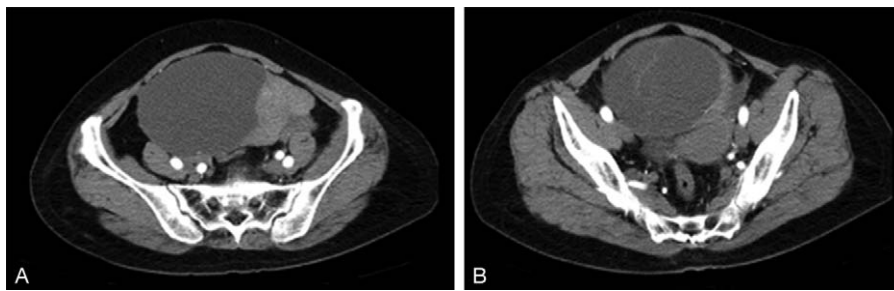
The images of pelvic ultrasonography and computed tomography. (A) A 13×9 cm sized multicystic tumor of left ovary. (B) A 16×9×14 cm sized multiseptated cystic mass with large enhancing solid portion in the left ovary.
